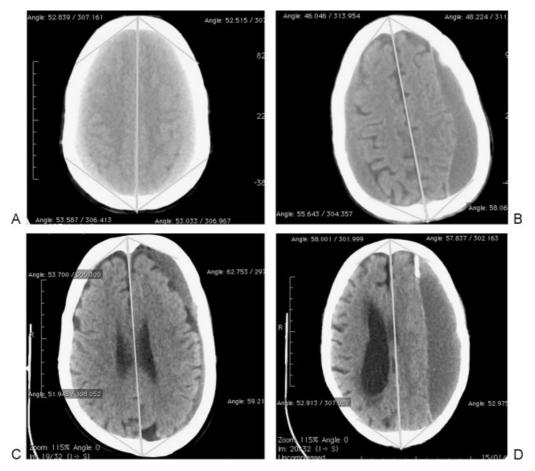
Axial sections of plain CT scan of the head show bilateral SDH with symmetric frontal and occipital angles (A), bilateral SDH with symmetric frontal but asymmetric occipital angles (B), unilateral SDH with asymmetric frontal and occipital angles (C), unilateral SDH with symmetric frontal and occipital angles (D).
